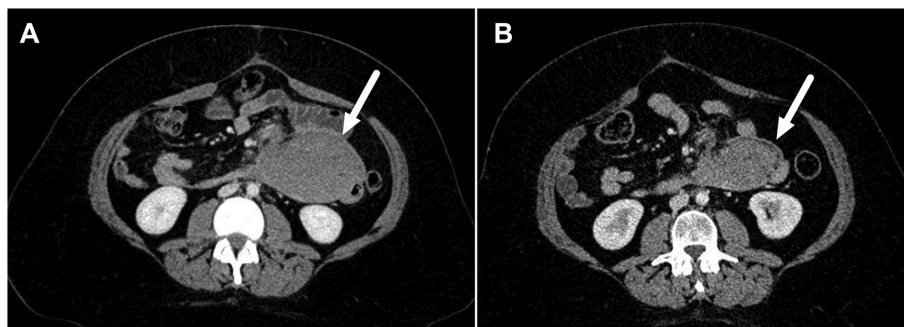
Patient with FAP-associated desmoid tumour treated with MTX+vinorelbine with partial response (PR). (A) CT scan before treatment; (B) CT scan at best response (PR) after 6 months of treatment.
